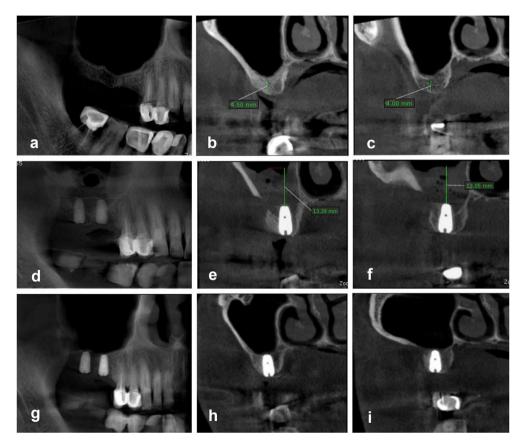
CBCT of patient I. (a) Panoramic view at  $T_x$ . (b, c) Cross-sectional views at  $T_x$  showing RBH of intended implants sites. (d) Panoramic view at  $T_0$  (e, f) Cross-sectional views at  $T_0$  showing ABH of both sites. (g) Panoramic view at  $T_6$ . (h, i) Cross-sectional views at  $T_6$  for both sites. ABH, apical bone height; CBCT, cone-beam computed tomography; RBH, residual bone height.
